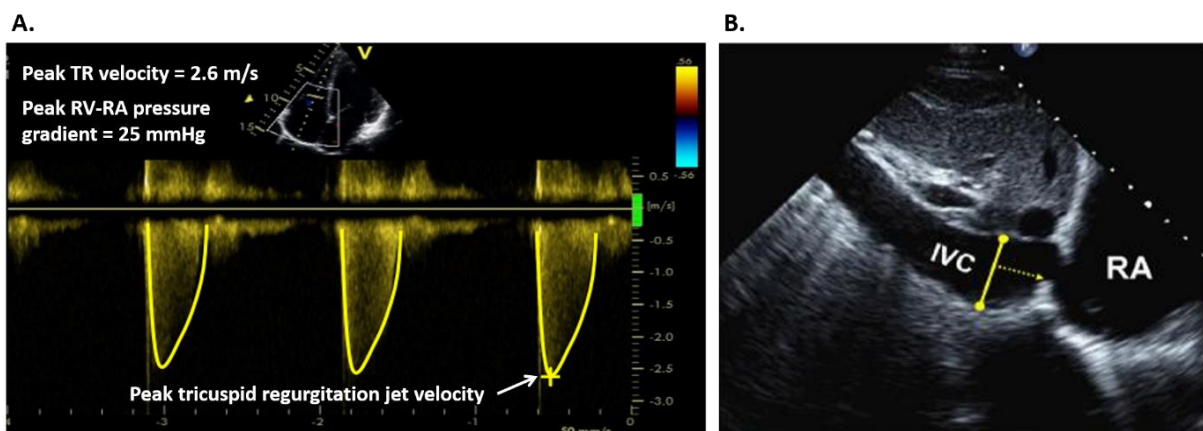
Estimation of pulmonary artery systolic pressure (PASP) via echocardiography.
